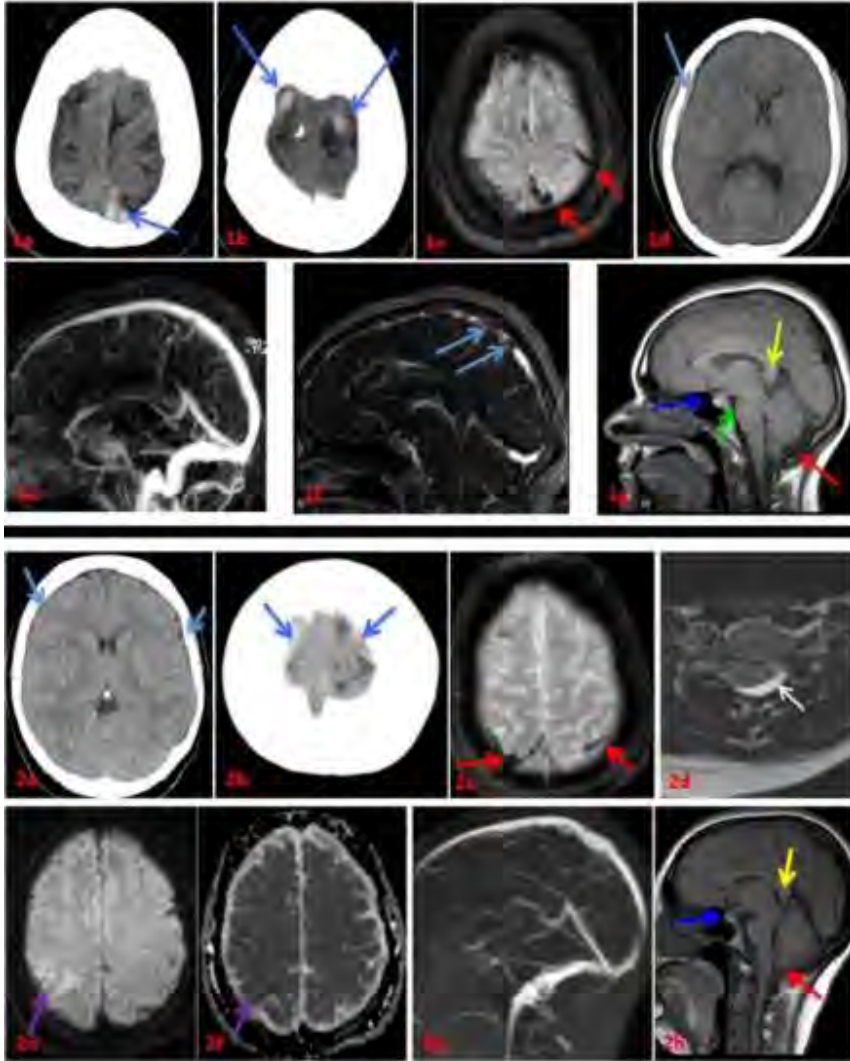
(from first postpartum patient): a-b: Small focal tubular hyperdensities (blue arrows) in the high parasagittal region likely represent thrombosed cortical veins. c: Increased susceptibility (red arrows) involving cortical veins in this region are also consistent with cortical venous thrombosis. d: Initial head CT demonstrated a right subdural collection of mixed density with acute subdural hematoma superficially and a low density collection deep likely reflecting a subdural hygroma (teal arrow) along the brain surface e: Reformatted MRV image demonstrates patency of dural venous sinuses. f: Parasagittal source image demonstrates thrombus in adjacent cortical veins (light blue arrows). g: T1 sagittal images demonstrate a relatively "closed" pons-midbrain angle (green arrow), splenium depressing the internal cerebral veins and vein of Galen junction (yellow arrow), and relative herniation of the cerebellar tonsils (red arrow), all of which are findings consistent with intracranial hypotension. Prominence of the pituitary (blue arrow) can be attributed to postpartum state and/or another finding of intracranial hypotension.
